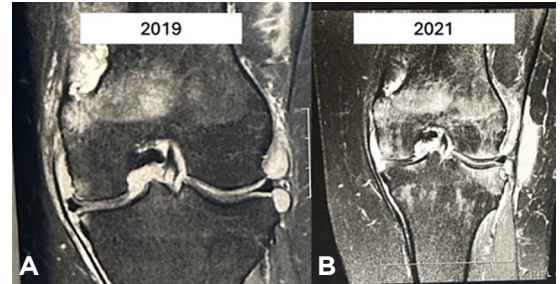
Changes on MRI images from 2019 to 2021. Advancement of bone compromise, including extension to the proximal tibia and distal femur.
